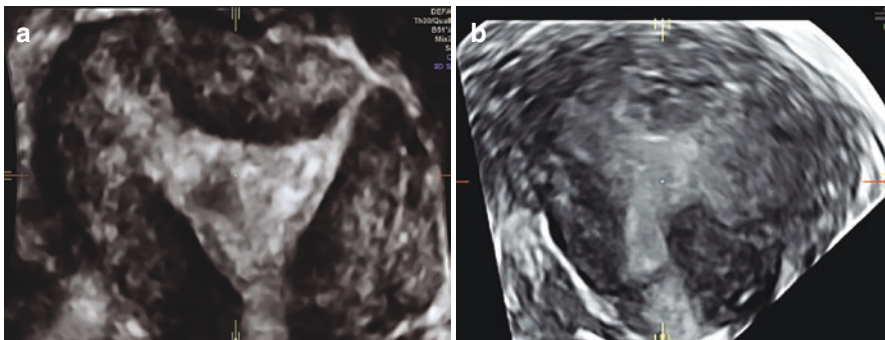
(a, b) Two 3D ultrasound images of diffuse adenomyosis of the JZ in coronal view. (a) partial invasion, (b) total infiltration of the JZ
